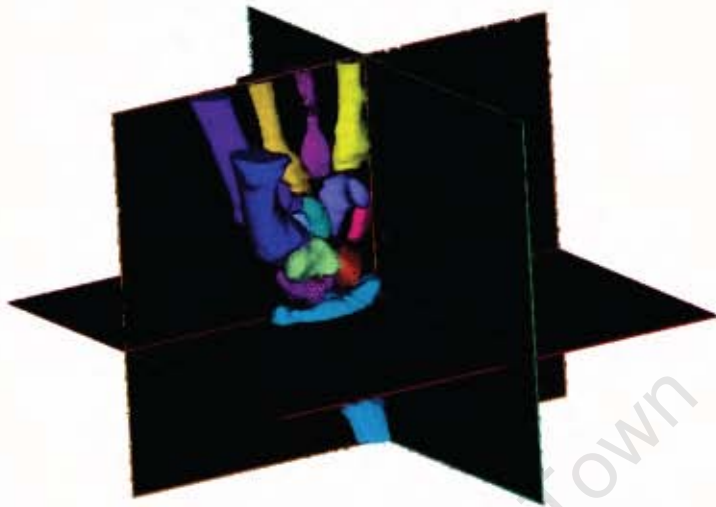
3-D Surface volumes of each bone created from CT-scan data in three different planes.
